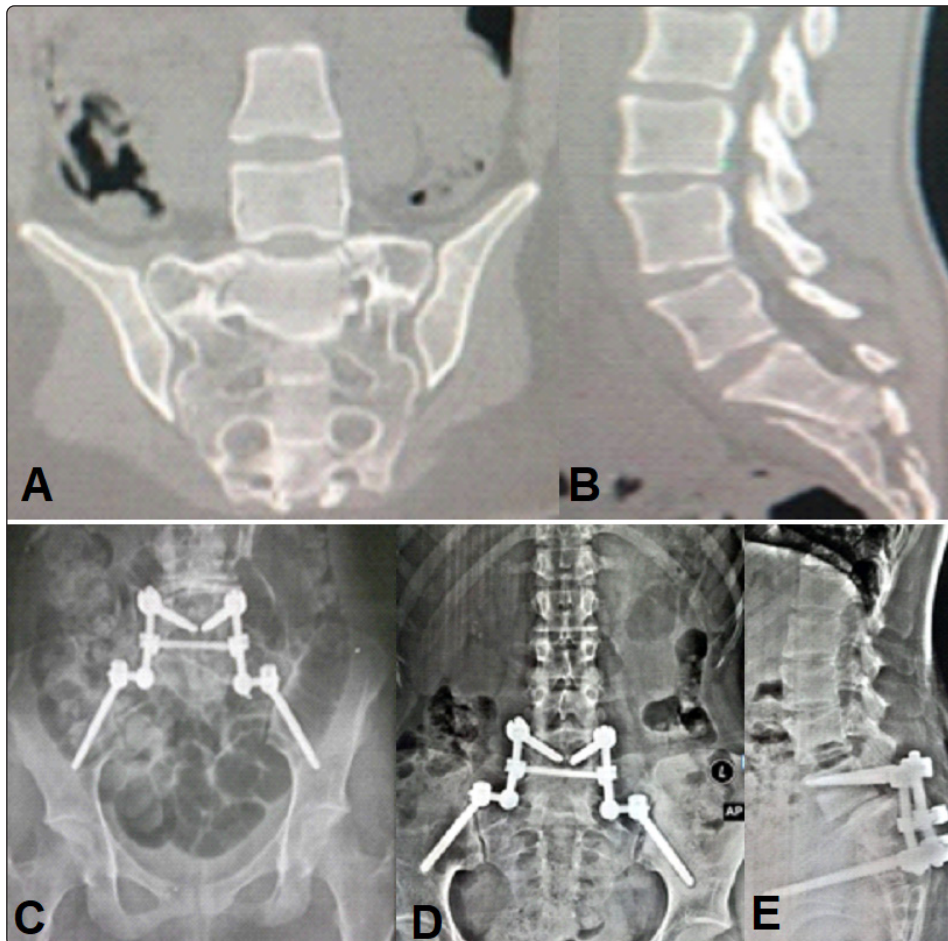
Images of (patient No. 9) 19 years old male patient presented after a fall from height with AO spine type C 3 sacral fracture, MSCT-Scan (A) Coronal and (B) sagittal images depicting a type-C3 sacral fracture, (C) 3 month postoperative AP view plain radiograph depicting lumbopelvic fixation, 12 months postoperative (D) AP view and (E) lateral radiographs showing stable construct with fracture healing.
